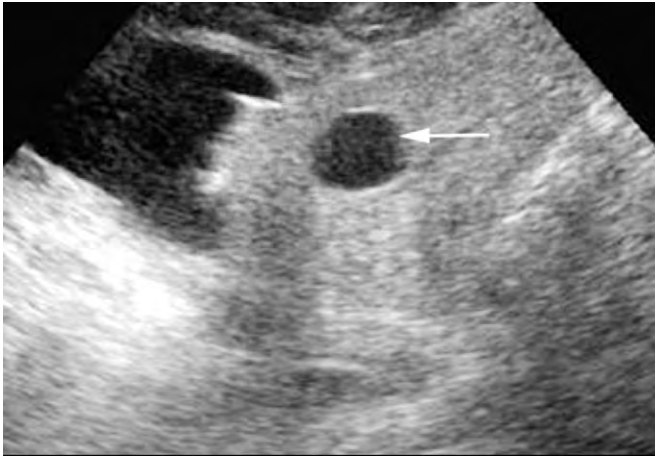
Simple hepatic cyst. Transverse ultrasound image of the left lobe shows an anechoic cyst (*arrow*) with smooth imperceptible walls and increased through transmission.
